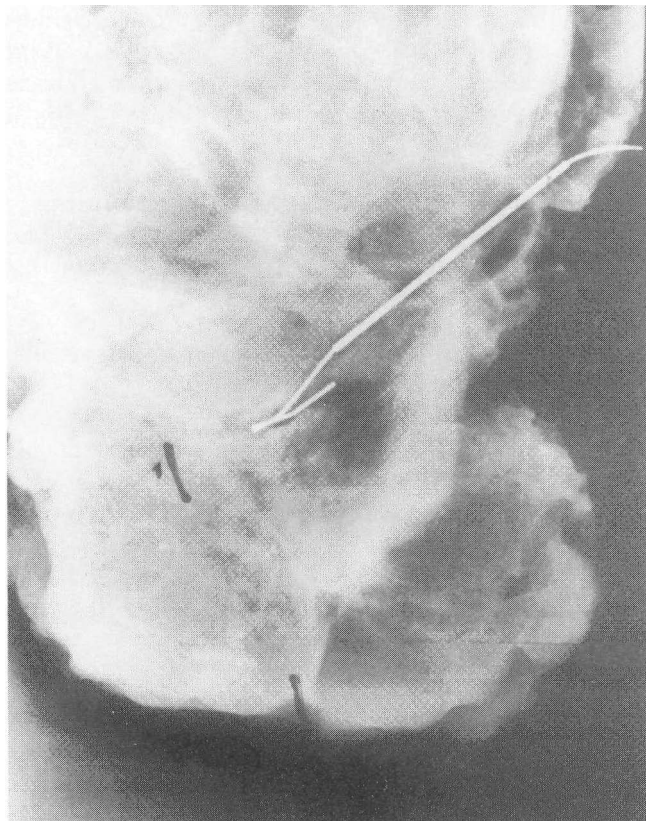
Breast cancer on x-ray
